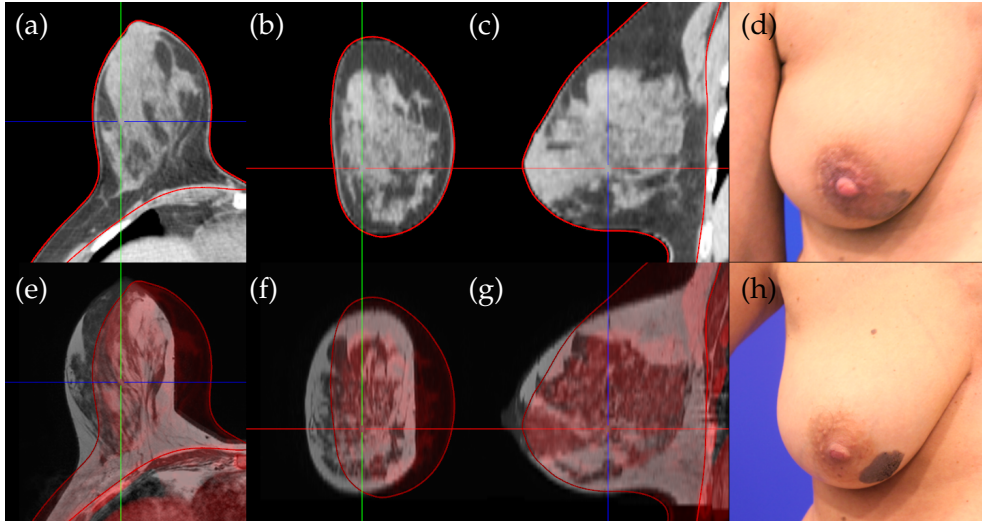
Prone post-surgical CT (a-c) and pre-surgical MR (e-g) image of the same patient with corresponding post-surgical (d) and pre-surgical (h) photographs respectively. The segmentation of the breast tissue in the CT image is contoured by a red outline. In the MR image a clear medial contact between the breast and coil can be observed medially resulting in significant deformation. Not all deformation can be attributed to the MR acquisition position since surgery took place between the MRI and CT acquisition, however pre-(h) and post-surgical (d) photographs indicate only minor influence on the shape due to surgery.
